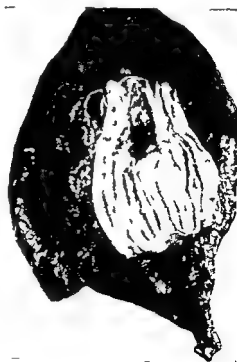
Roentgen film of a patient with Type 2 achalasia treated five years previously by esophagomyotomy showing large annular filling defect in the superior mediastinal segment produced by a carcinoma
